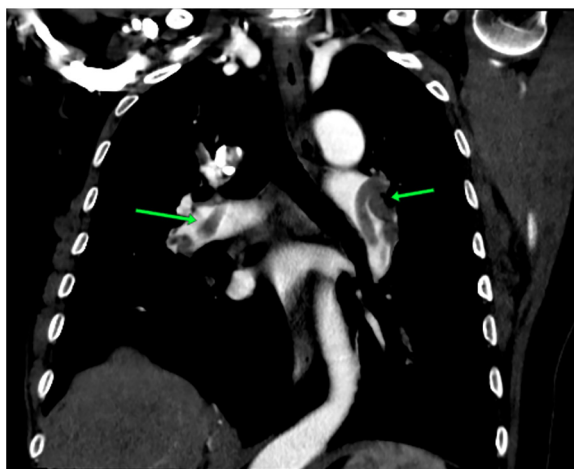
Computed tomography pulmonary angiography, axial section, indicating filling defects in both right and left pulmonary arteries and acute pulmonary embolism (green arrows).
